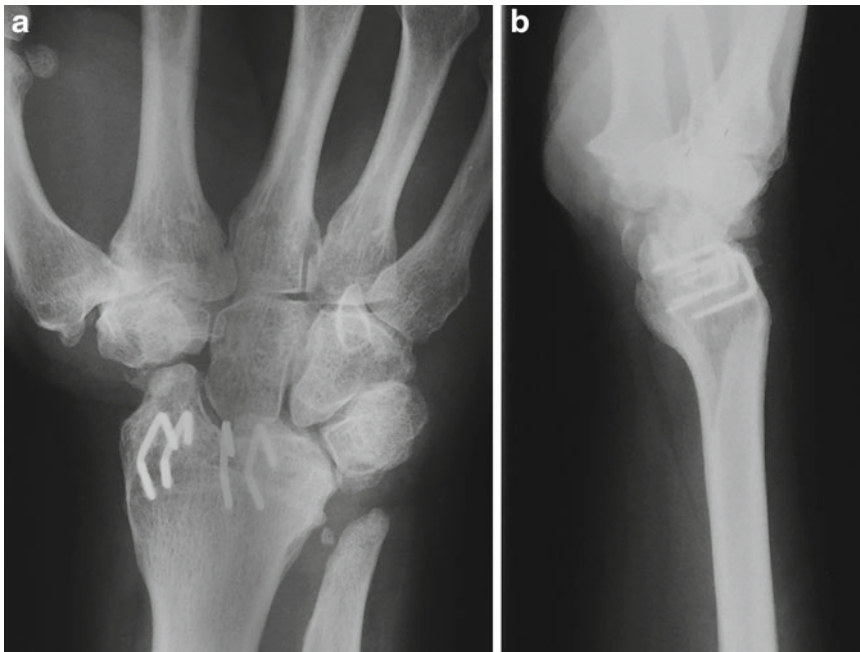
(a) Patient 3: Plain radiograph demonstrating solid RSL fusion with distal scaphoid excision and ulnar hemiresection. There is preservation of the midcarpal
